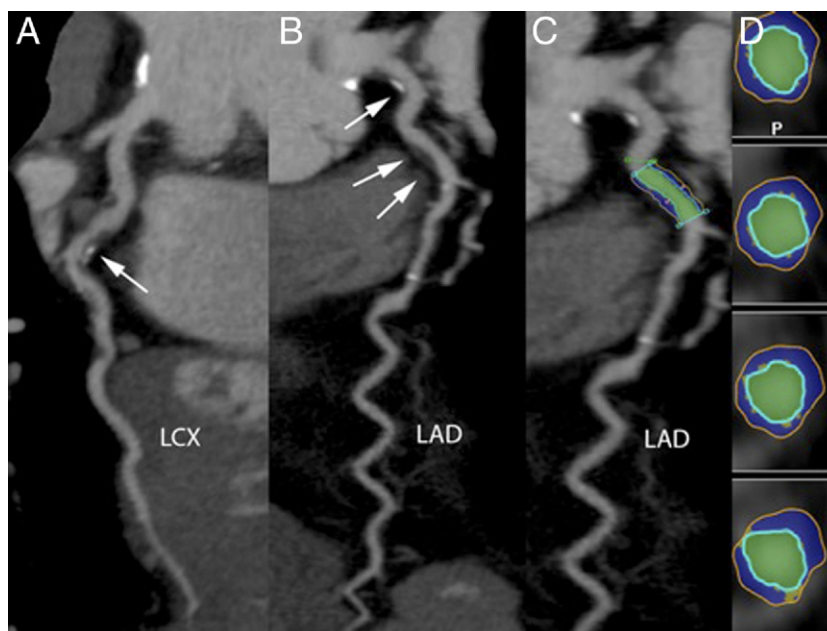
Evaluation of Coronary Plaques With Computed Tomography
